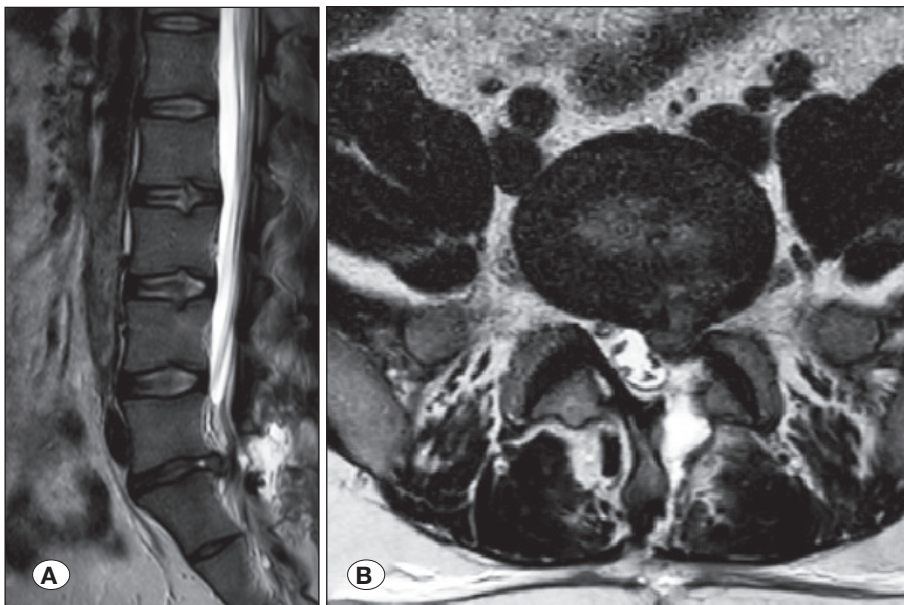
Early recurrent lumbar disc herniation; A) sagittal and B) axial T2W MRI scans of L5-S1 early recurrent disc herniation.
